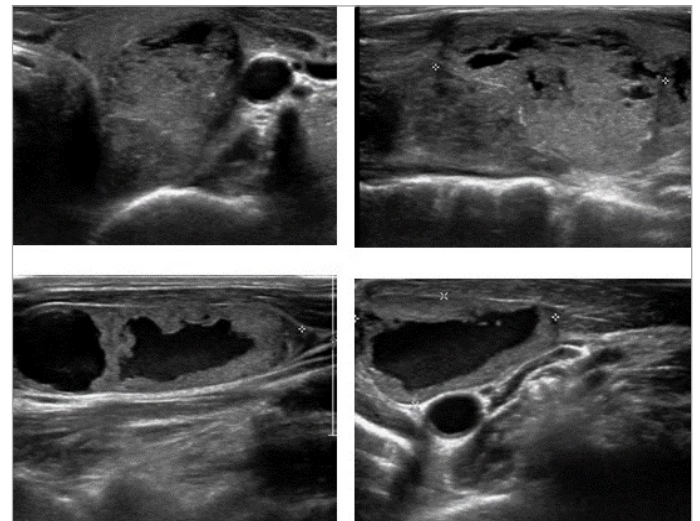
Neck ultrasonography on first visit, showing thyroid nodules with suspicious malignant lymph nodes.
